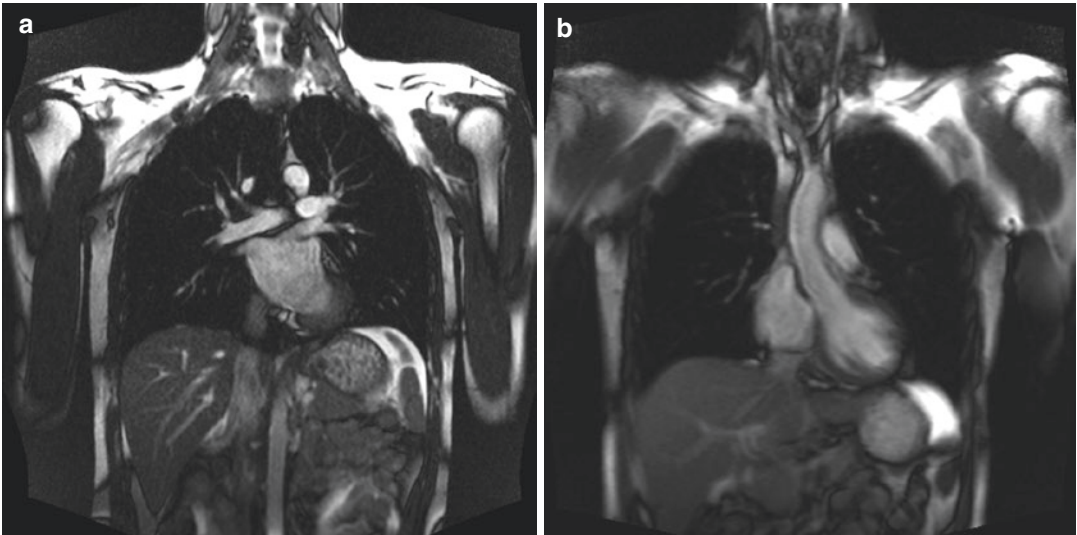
T1/T2-weighted steady-state gradient echo sequence (TrueFISP), (a) coronal acquisition in free breathing to cover the whole chest in a semi-dynamic acquisition, (b) coronal acquisition in forced respiratory
